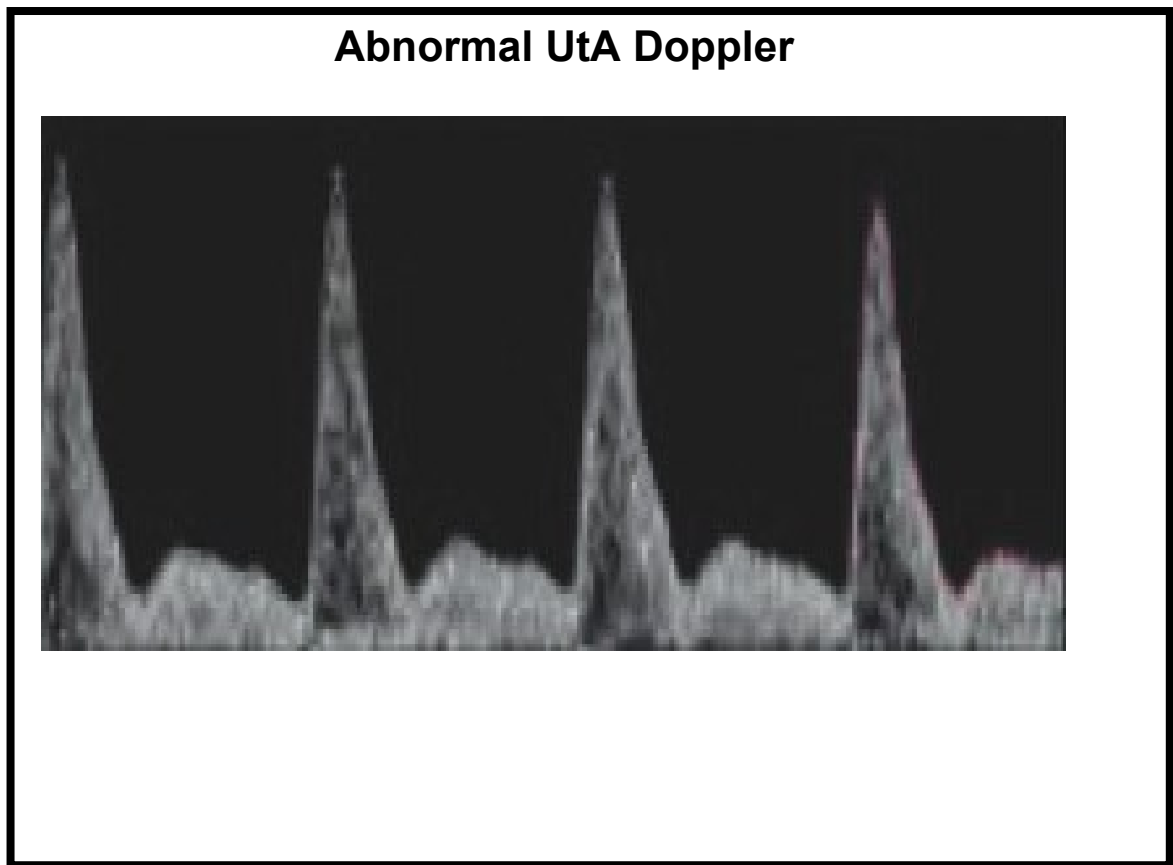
Abnormal uterine artery Doppler waveform (adapted from Bruin et al, 2021)³⁹
